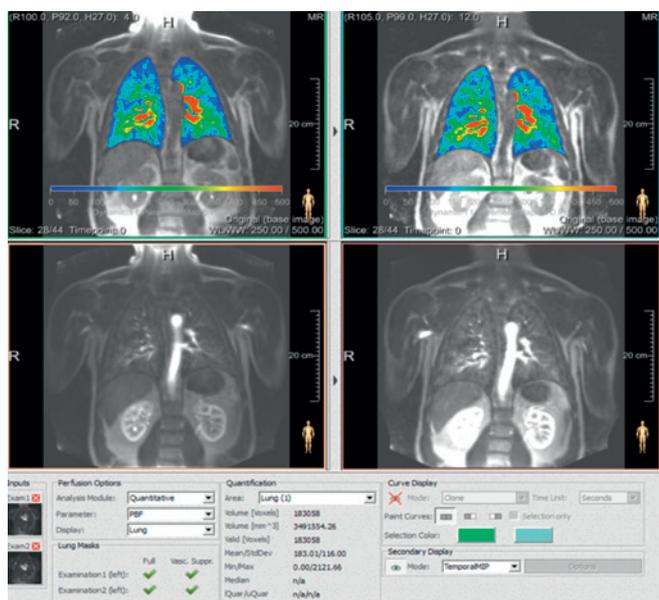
Quantitative Analysis of Perfusion-MRI “Pulmo-MR” (MeVis/Bremen)
